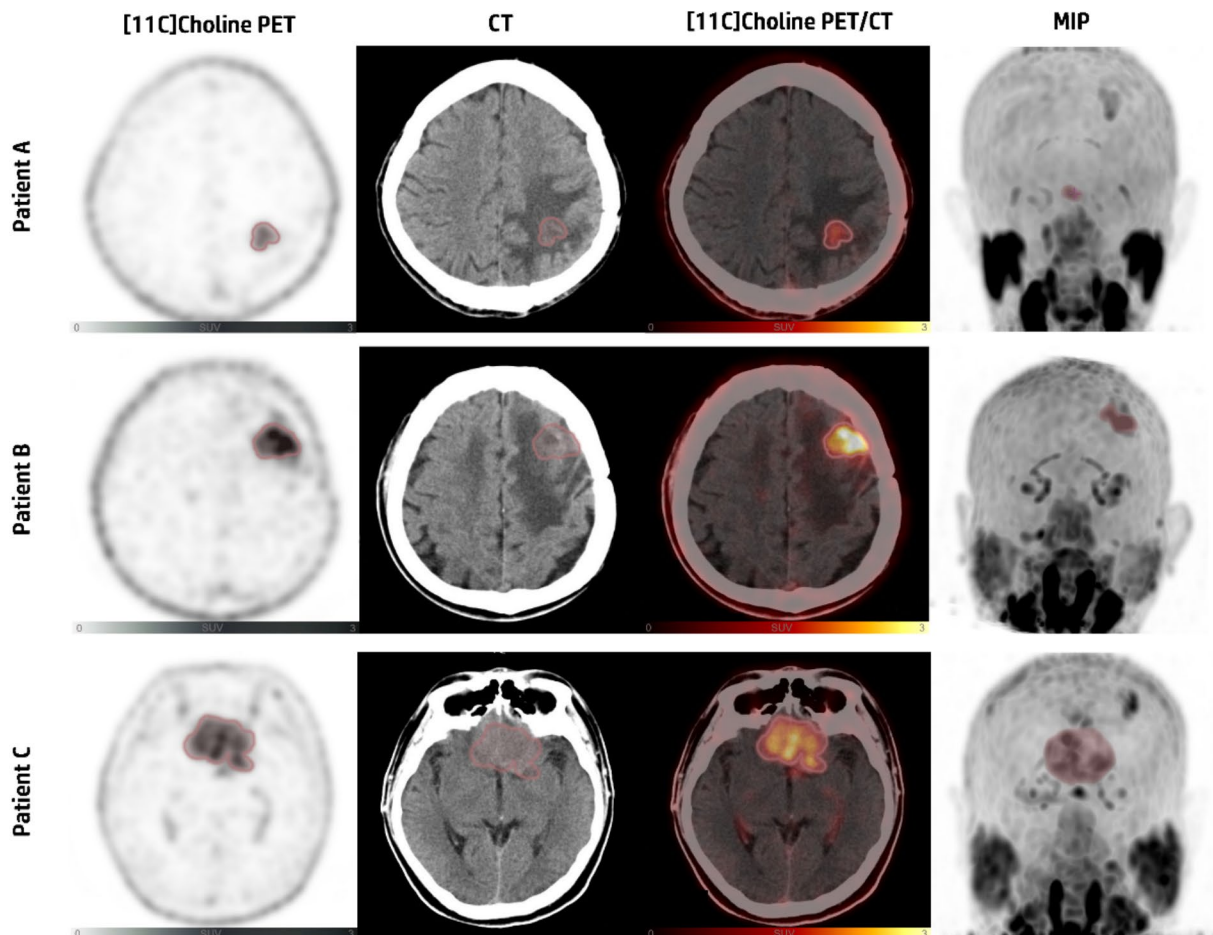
Patient A: a 41-year-old male diagnosed with mixed oligodendroglioma (WHO grade II), underwent surgery followed by radiotherapy. ^{11}C -choline PET/CT imaging showed increased tracer uptake in the left frontal lobe (SUV_{max}=2.10; SUV_{mean}=1.22; MTV=4.88cm³). Follow-up: Alive, survival period of 38 months
